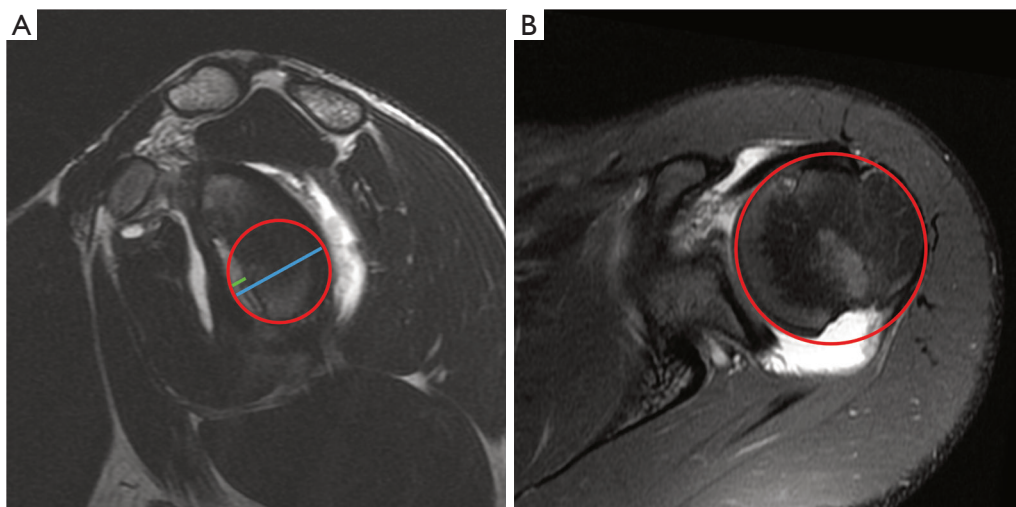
MRI assessment of glenoid and humeral bone loss. (A) Assessment of glenoid bone loss with the “best-fit circle” technique. The red circle represents the best-fit circle. The green line is reported to the blue line to evaluate the percentage of glenoid bone loss. (B) For assessment of humeral bone loss, a circle in red is drawn to fit the humeral head allowing to measure the depth and width of the Hill-Sachs. MRI, magnetic resonance imaging.
